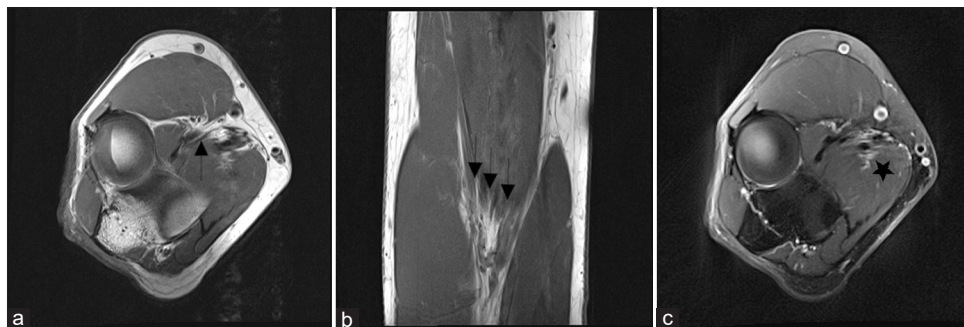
Preoperative MR neurogram of the right elbow. Axial T1 MR images (a) demonstrating a thin fat pad (arrow) between the biceps aponeurosis and underlying neurovascular bundle. (b) T1 coronal MR imaging demonstrates three distinct tendons forming the biceps aponeurosis (three arrows). (c) T2 axial demonstrates subtle enhancement of the median nerve (star).
